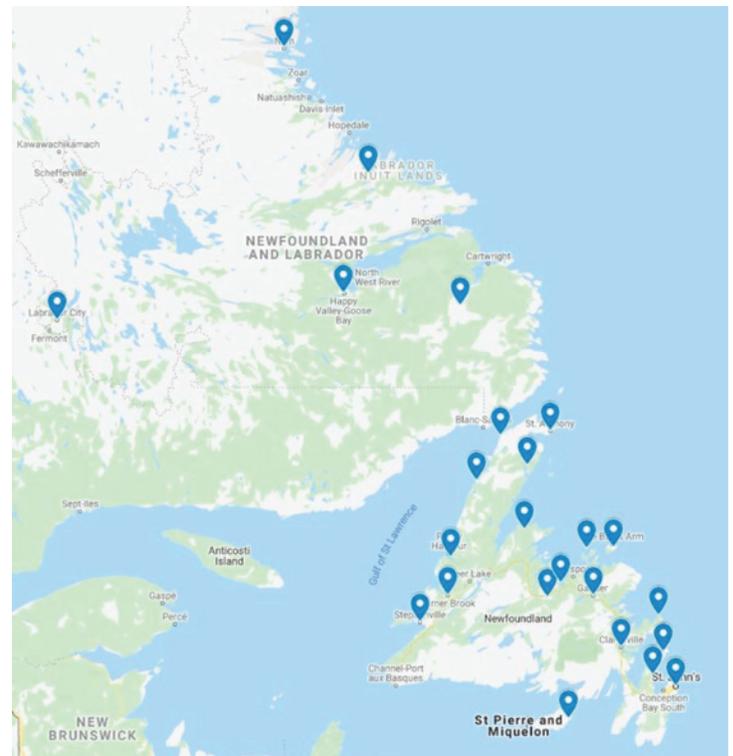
Location of Point-of-Care Ultrasonography Devices in NL
